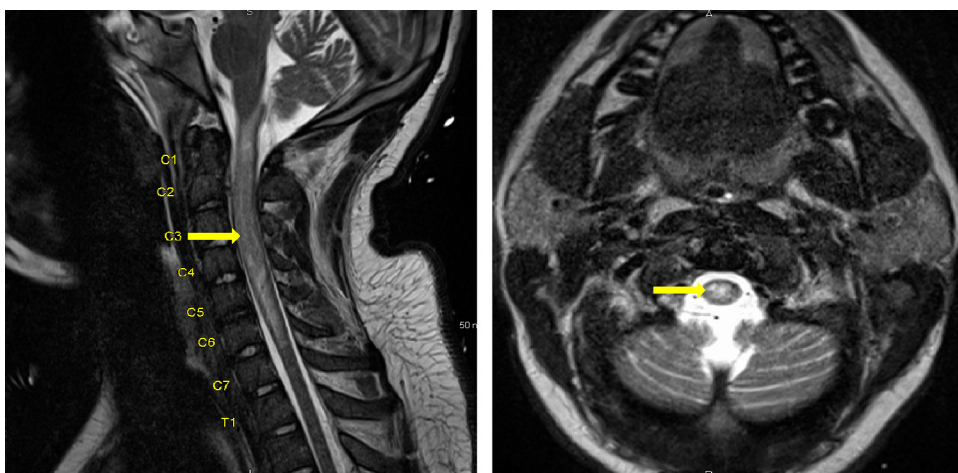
MRI of cervical spine with intravenous contrast done after 12 days with cystic myelomalacia indicated by the arrow.
